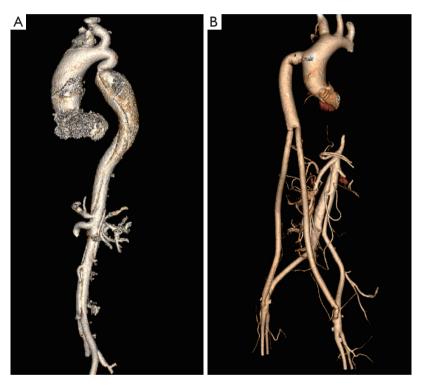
Pre- and post-operative imaging of patient No. 11. (A) Preoperative CTA demonstrating that the dissection is extensive, reaching to iliac artery; (B) post-repair CTA demonstrating the proximal descending aorta completely thrombosed. CTA, computed tomography angiography.
